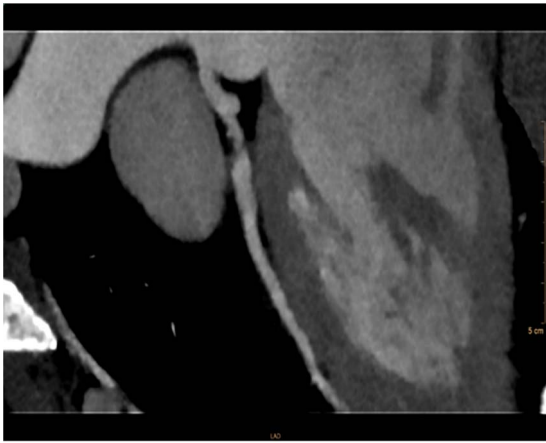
Computerized tomography (CT) coronary angiogram. 15 mm non-calcified lesion from ostial to proximal left anterior descending (LAD) coronary artery causing moderate to severe stenosis.
